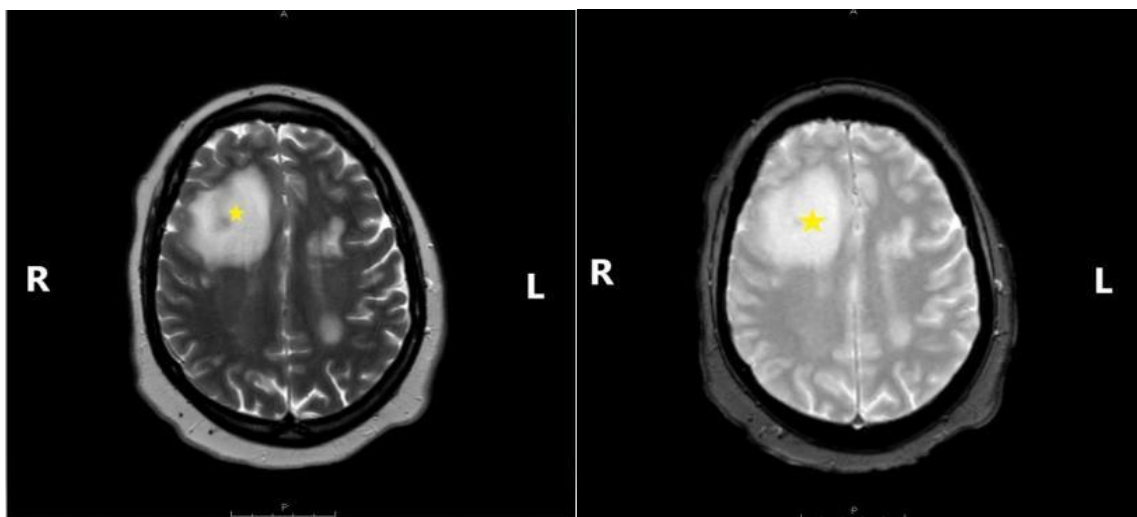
CT Head with lesion and mass effect (star).
